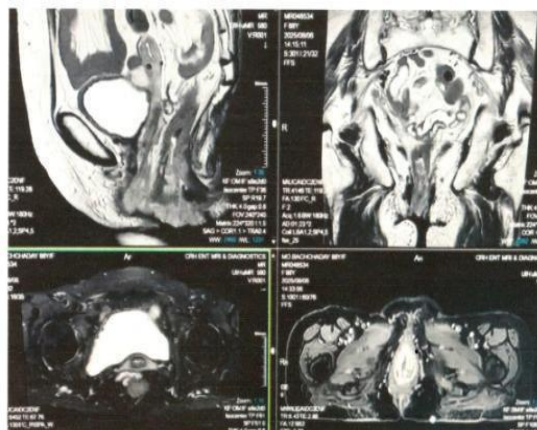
CE- MRI of Pelvis: B/L Atrophic Ovaries. Lobulated Solid Mass. Vulva and Introitus 6x2x2 cm, locally advanced: B/L Sub-centric inguinal nodes.
